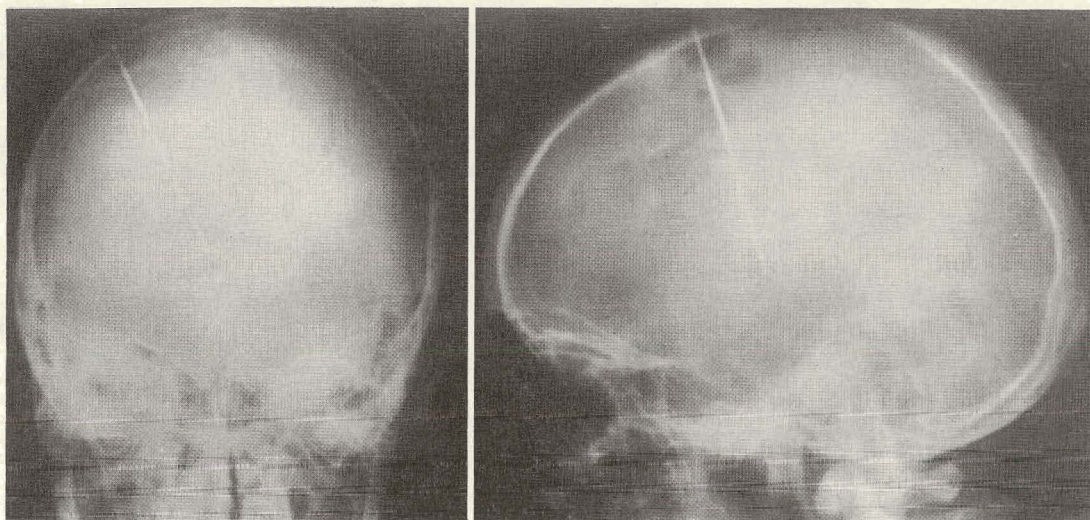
Roentgenogram of needle in position. The small isotope is scarcely visible beyond and a little to one side of the tip of the needle.
